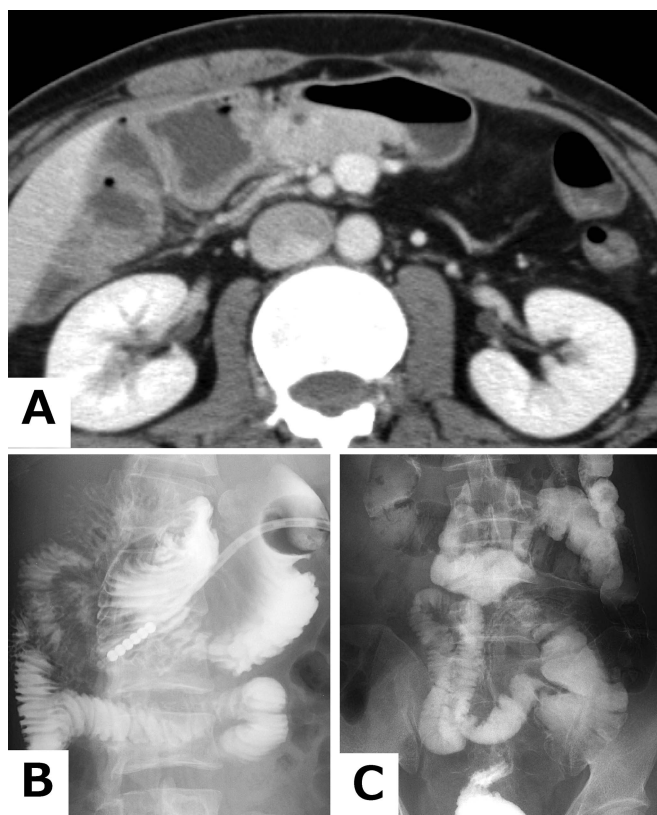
Preoperative imaging study during fifth admission. A. Enhanced CT: SMV rotation sign. B. Upper gastrointestinal series (right anterior oblique position): a right-sided small bowel. C. Enema (supine position): a left-sided entire colon.
